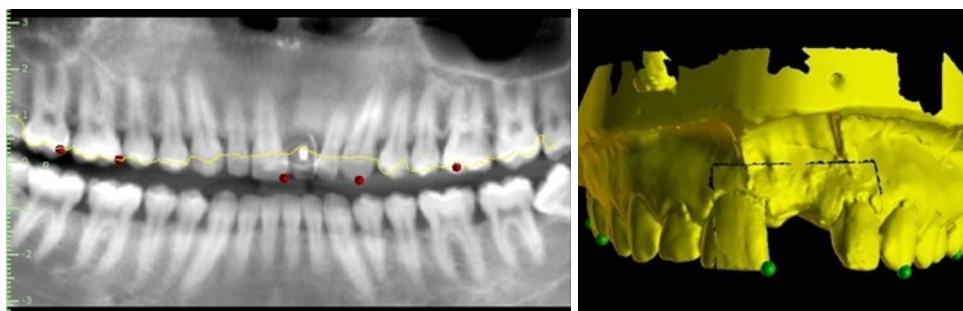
Matching the CBCT and the virtual cast to obtain their superimposition.
